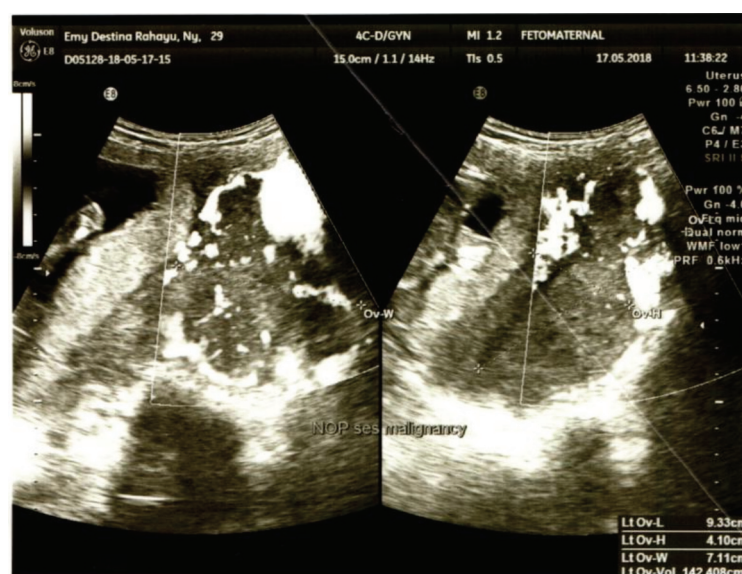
This figure shows the ultrasound examination in the 19th gestational week which showed a homogenous solid mass in the left adnexa measuring 93×41×71 mm.
